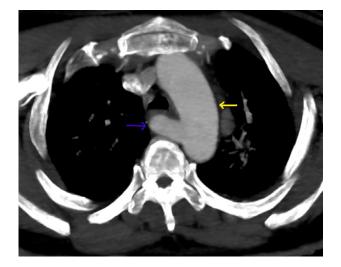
Postcontrast computed tomography—angiography axial image demonstrates the presence of an Arteria lusoria (aberrant right subclavian artery) (blue arrow) which originates from the aortic arch (yellow arrow).
